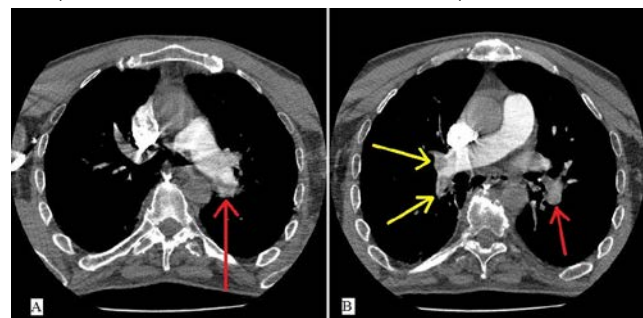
Horizontal views of pulmonary CT angiography (with PTE protocol). Left main pulmonary artery (A, red arrow) and right pulmonary artery (B, yellow arrow) are partially obstructed by thrombosis and distal branches of left pulmonary artery (B, red arrow) are completely blocked. All these findings reflect Qanadli score of more than 20 out of 40. Qanadli index of greater than 40% provides an accurate method for diagnosis of massive pulmonary embolism.
